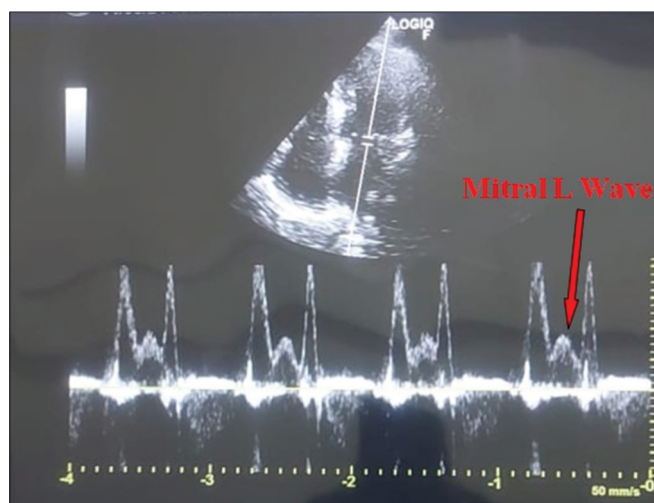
Pulsed-wave Doppler tracing of transmitral inflow showing the mid-diastolic mitral L-wave (between the E and A waves)
